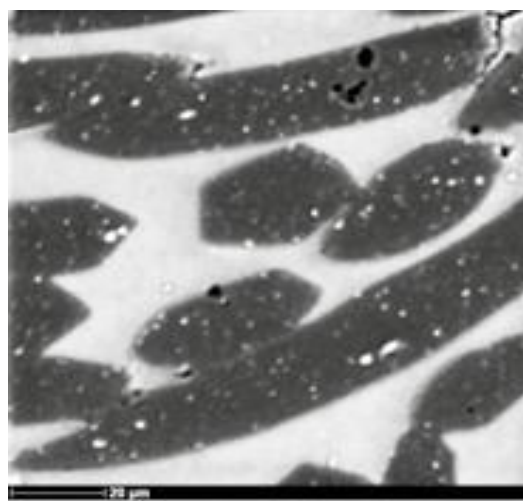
shows an x-ray of the ceramic powder (white flecks) melted onto the base fabric
